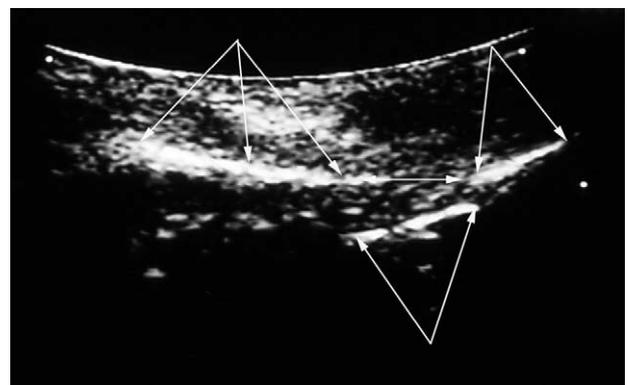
Ultrasound image of a fracture of the medial orbital rim. The double arrow shows the dislocation of the fracture. The lower arrow shows the dislocated fragment. The upper arrow show the unfractured area of the medial orbital wall.
